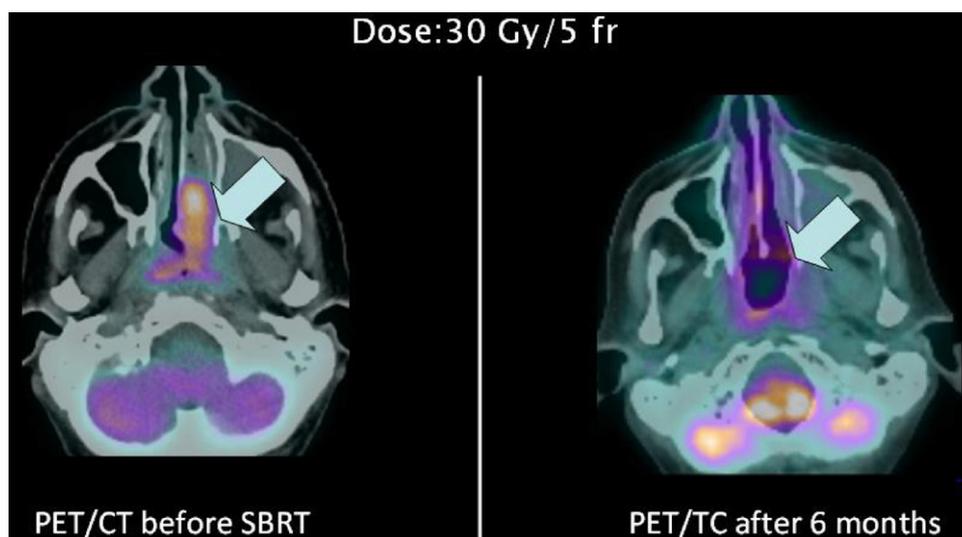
Case 2: Direct comparison of PET/CT images before and 6 months after the SBRT treatment (30 Gy in 5 fractions), showing (with white arrows) a complete response in the site of nasopharynx relapse.
